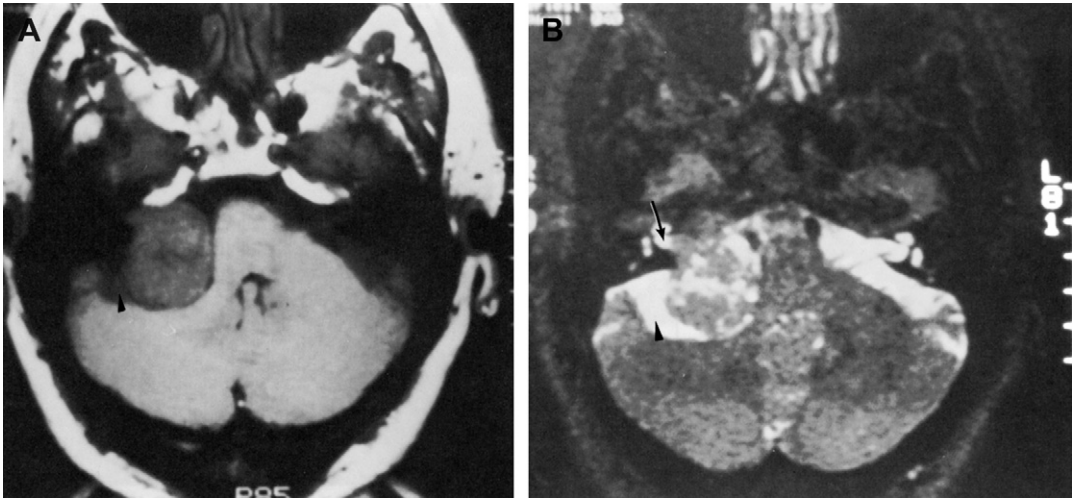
(A) T₁-weighted magnetic resonance image (unenhanced); large acoustic neuroma is seen filling the internal auditory canal (IAC) and cerebellopontine angle cistern. The pons and the cerebellar peduncle as well as the fourth ventricle are pushed toward the contralateral side. There is a collection of cerebrospinal fluid (CSF) (*arrowhead*) posterolateral to the acoustic neuroma. (B) T₂-weighted image shows the acoustic neuroma in the cistern protruding into the IAC. A small amount of CSF is trapped in the lateral aspect of the IAC (*arrow*), thus the tumor is not completely filling the canal. The fluid collection posterolateral to the neuroma (*arrowhead*) shows the same brightening as the CSF.
